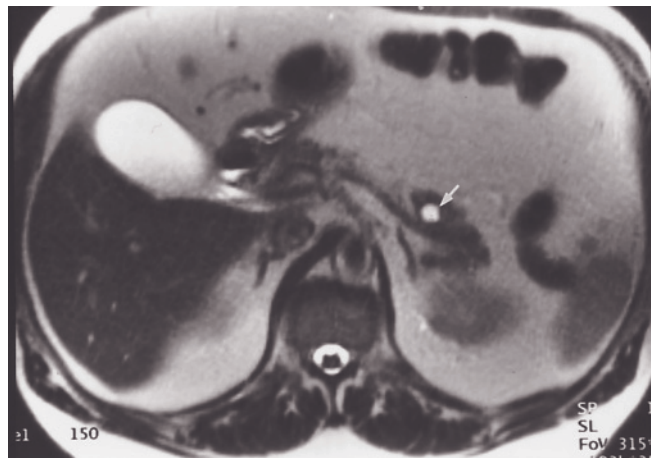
(Continued) uniformly high in signal intensity on T2-weighted (*e, f*) and interstitial-phase gadolinium-enhanced T1-weighted (*g*) images. Stricture of the fourth part of the duodenum (large arrow, *e*) reflects peptic ulcer disease in Zollinger-Ellison syndrome. Two prior CT imaging examinations were reported as negative.
